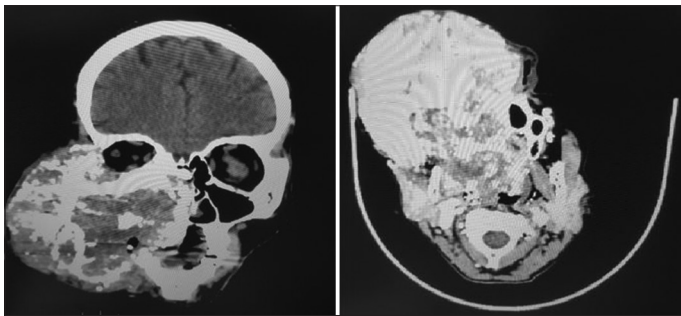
Contrast-enhanced computed tomography images of facial bones show exophytic mass with destruction of right orbit, ethmoid, turbinates, nasal septum, nasal cavity, maxilla, and maxillary sinus
